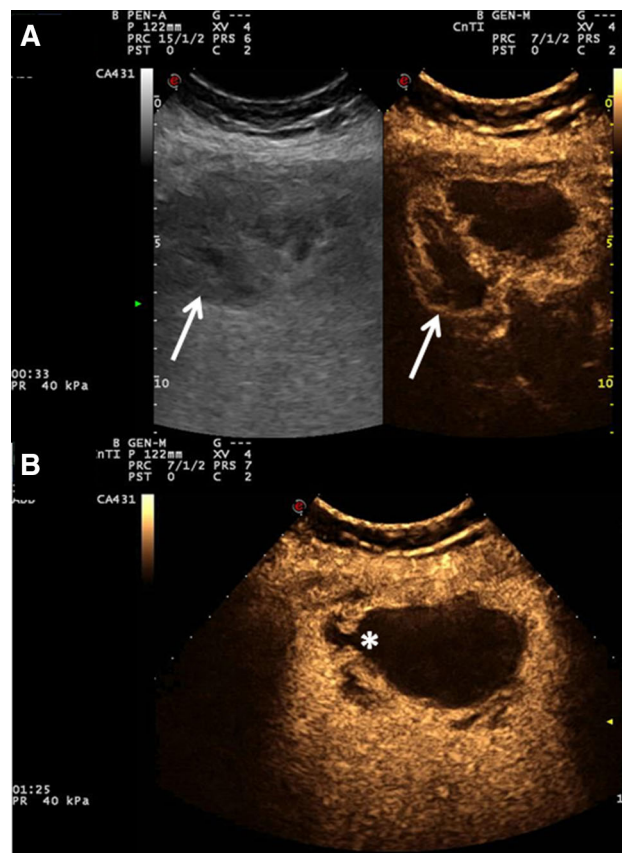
A 67-year-old man with gallbladder perforation complicating acute cholecystitis. On panel a CEUS confirms the defect in the gallbladder wall (*asterisk*), while on B-mode US gallbladder walls are vaguely defined and irregularly striated and thickened (image on the *left* in the real-time dual imaging with CEUS). CEUS suggests a walled-off perforation, confirmed by contrast-enhanced CT scan and surgery
